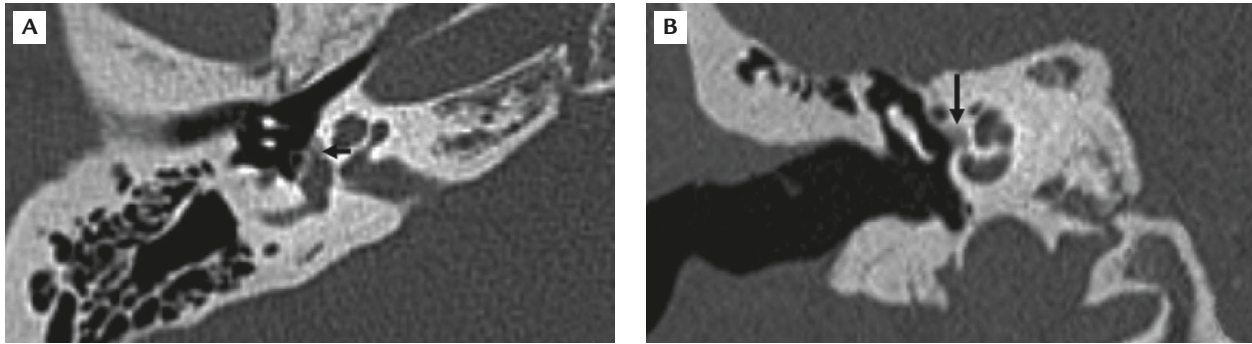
High-resolution computed tomography shows focus of hypodensity (arrows) at the fissula ante fenestram (anterior to the oval window): (A) axial view; (B) coronal view.
